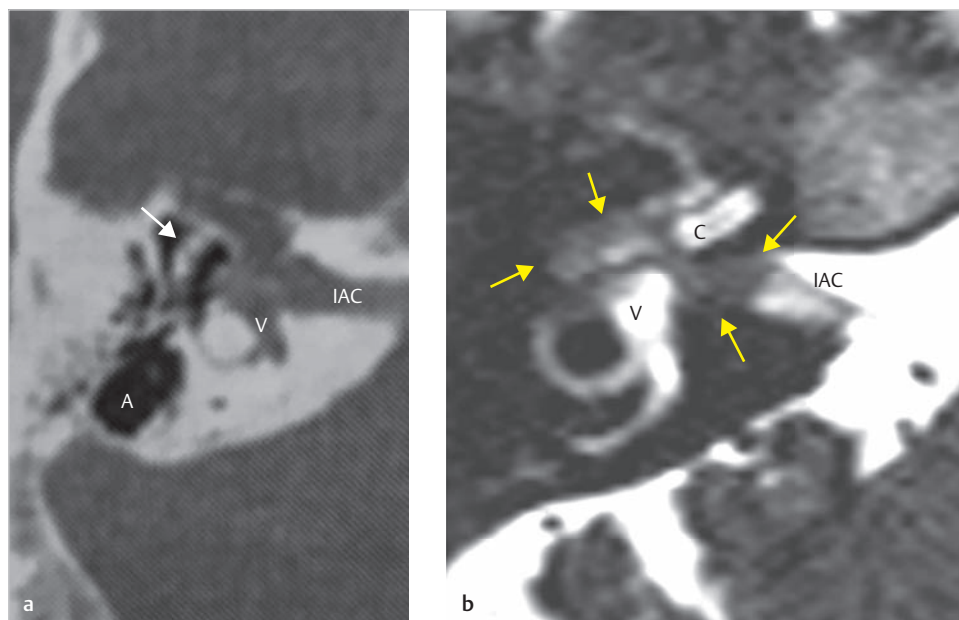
The preoperative axial CT (a) shows presence of bone erosion in the vestibule and the lateral part of the internal auditory canal. No cholesteatoma is seen near the ossicular chain (white arrow) and the antrum. The T2-weighted MRI (b) shows medial extension of the cholesteatoma (yellow arrows) surpassing the labyrinth invaginating into the lateral end of the external auditory canal. A, antrum; C, cochlea; IAC, internal auditory canal; V, vestibule.
